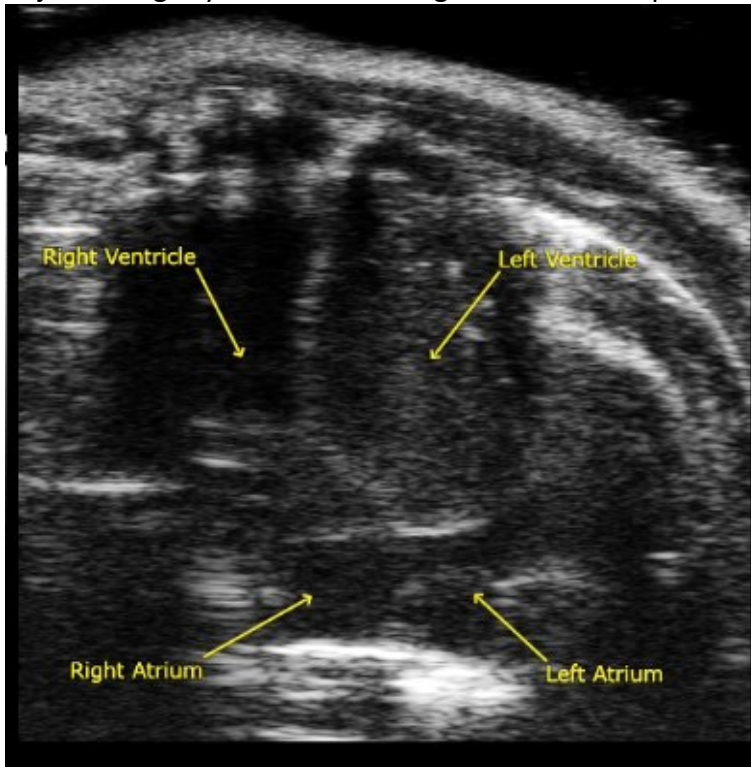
Apical four-chamber view
